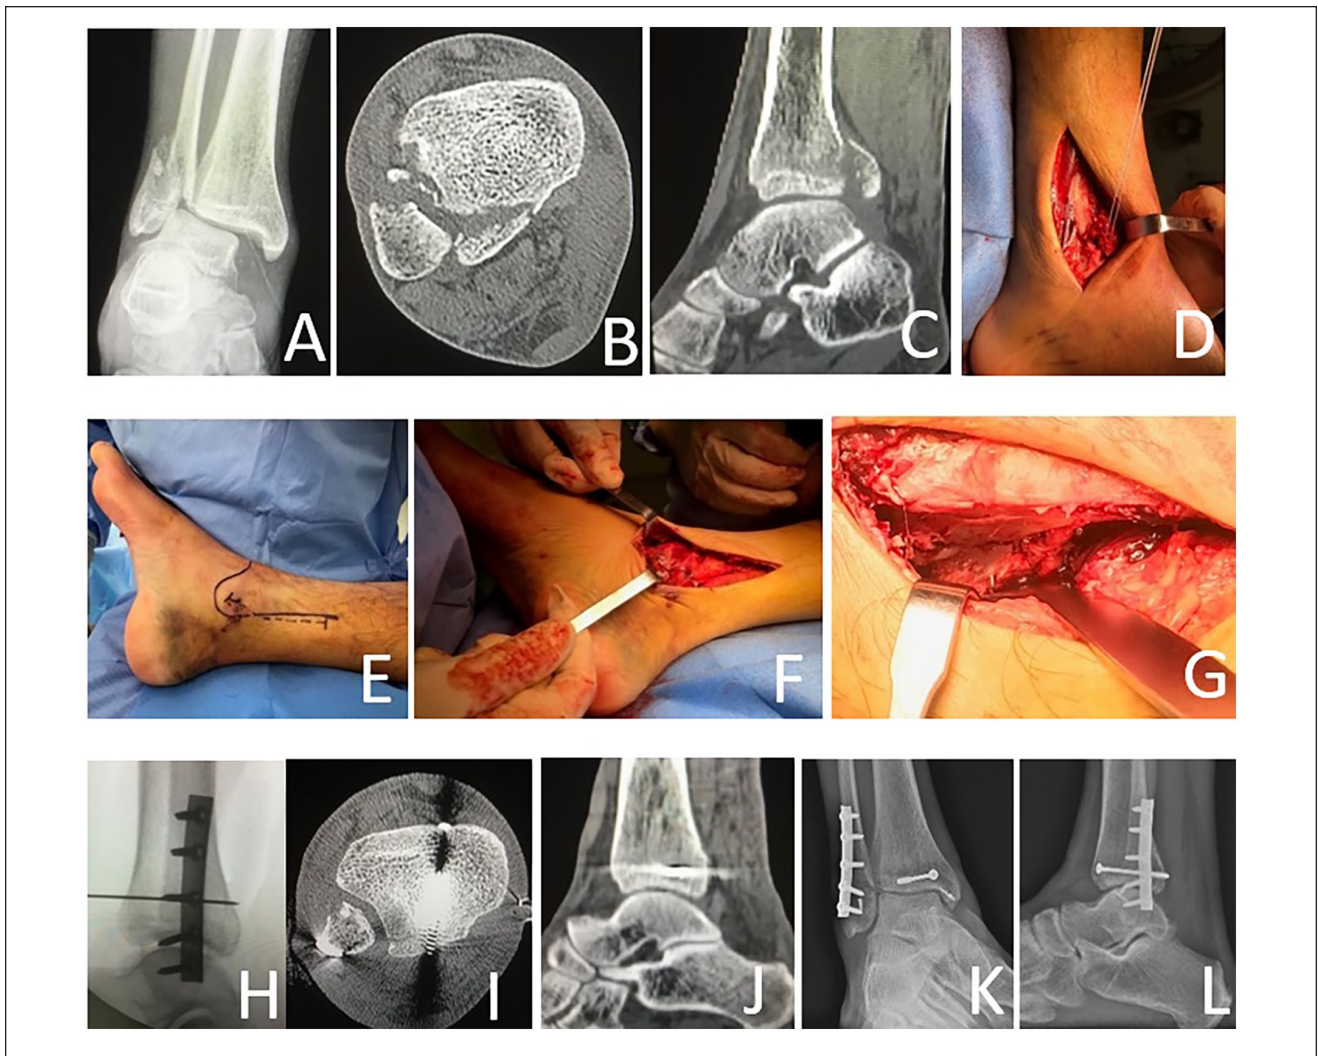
(A, B, C) Patient with a Bartonicek II posterior malleolar fracture. (D) Direct lateral approach to fix the fibula and repair the anterior-inferior talofibular ligament with an anchor. (E) Modified posteromedial approach. (F) Deltoid ligament repair. (G, H) Visualization of posterior malleolus fragment and transitory reduction of the posterior malleolus with an AP Kirschner (K)-wire. (I, J) Axial and sagittal postoperative computed tomographic scan showing anatomical reduction and stable fixation with an AP screw. (K, L) Standing postoperative radiographs showing stable reduction at follow-up time. AP, anteroposterior.
